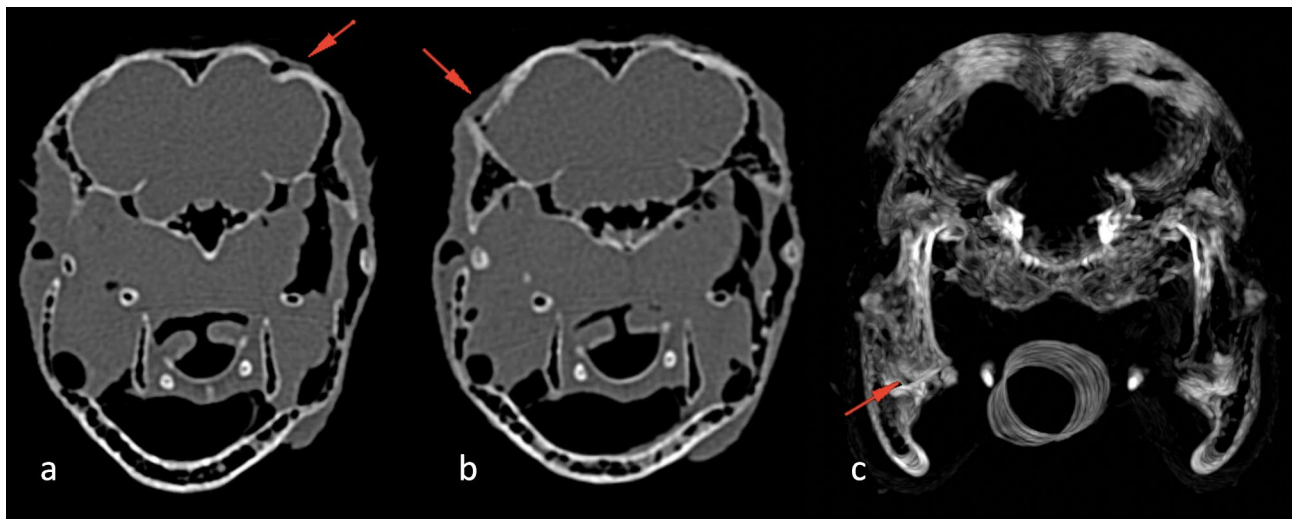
Transverse CT sections showing the left parietal (a) and right temporo-occipital (b) calvaria fractures (red arrows). Transverse CT section in MIP obtained after manual reduction of the quadrate luxation, showing normal repositioning of the quadrate bone in the quadratic fossa (c)
